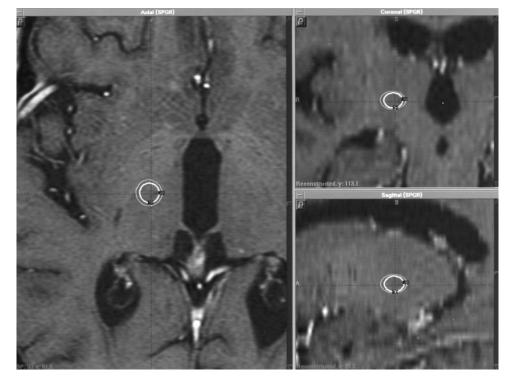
GammaPlan software snapshot showing MRI SPGR images in axial poster (left) with coronal (upper right) and sagittal (lower right) reconstruction. Using stereotactic coordinates, the 50% isodose line of a single 4-mm collimator shot is placed to target the right vim nucleus.
